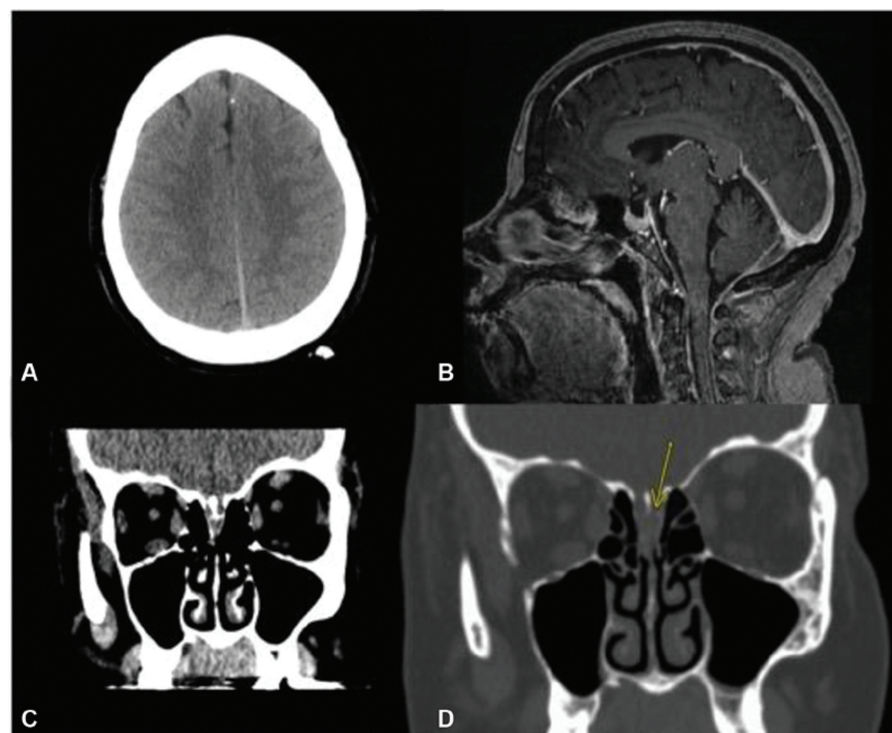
(A) An axial slice from computed tomography (CT) of the head demonstrates a thin parafalcine subdural hematoma at time of presentation. (B) A sagittal image taken from T1-weighted brain magnetic resonance imaging (MRI) after gadolinium contrast administration shows a partially empty sella. (C) A coronal slice from a thin-cut CT of the head shows a bony defect of the right lamina papyracea with trace mucosal thickening in the right sphenoid sinus and left maxillary sinus. (D) Bone-windowing of the aforementioned image shows soft tissue or fluid immediately subjacent to the cribriform plate bilaterally, inferior to the olfactory bulb region in the olfactory recess of the nasal vault (arrow), suggestive of a bony defect in the left cribriform plate.
